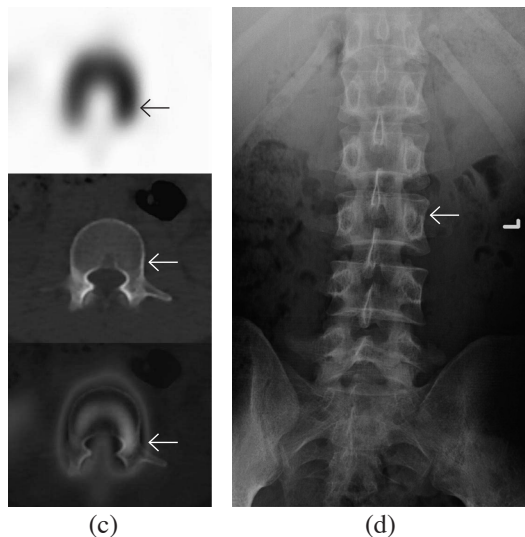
(c) Evolution SPECT/CT images revealed slightly increased radiotracer uptake at left pedicle of L3 vertebra without definite bony destruction. (arrow) This lesion was concluded as probably a metastatic lesion. (d) Plain radiograph performed 2 months later demonstrated an osteolytic lesion at left pedicle of L3 vertebra (arrow).
